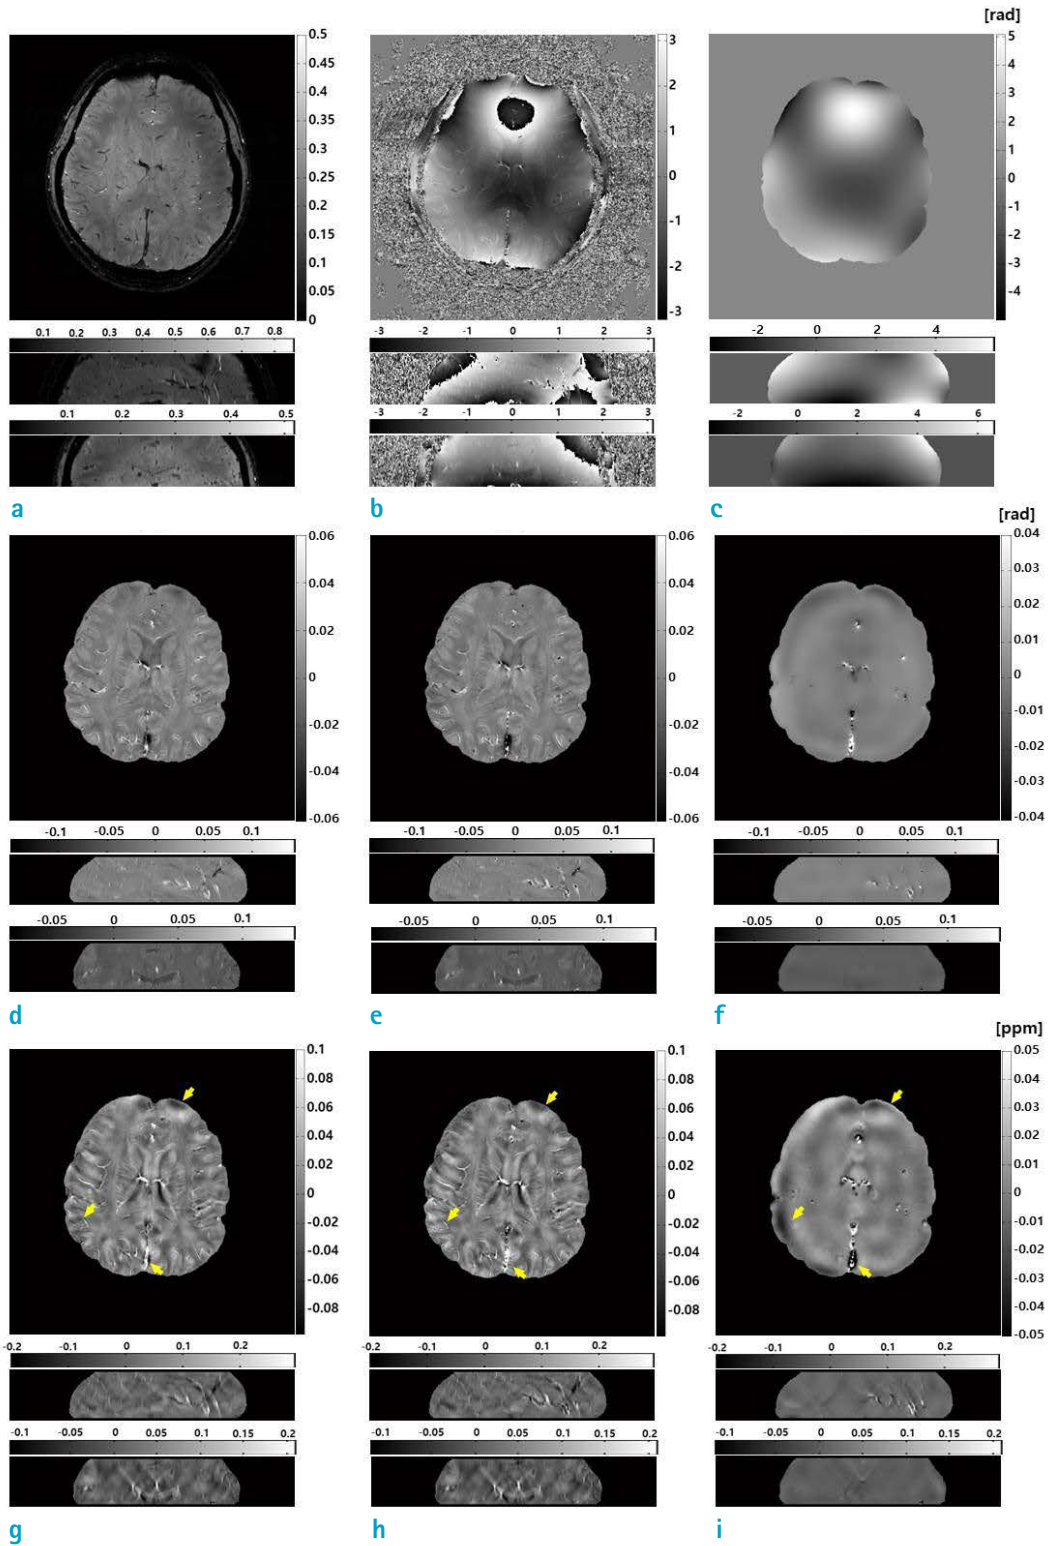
In vivo* QSM imaging for 7.0T MRI. Axial, sagittal, and coronal planes are shown from top to bottom: (a) magnitudes, (b) wrapped phases, (c) estimated inhomogeneity by SUPER, (d) and (g) tissue susceptibility-induced phase and the susceptibility map without global inhomogeneity correction, (e) and (h) tissue phase and susceptibility map with the global inhomogeneity correction, and (f) and (i) differences between the two phases and the susceptibility maps, respectively. Regions of distinct differences in the susceptibility maps are marked with small arrows.
